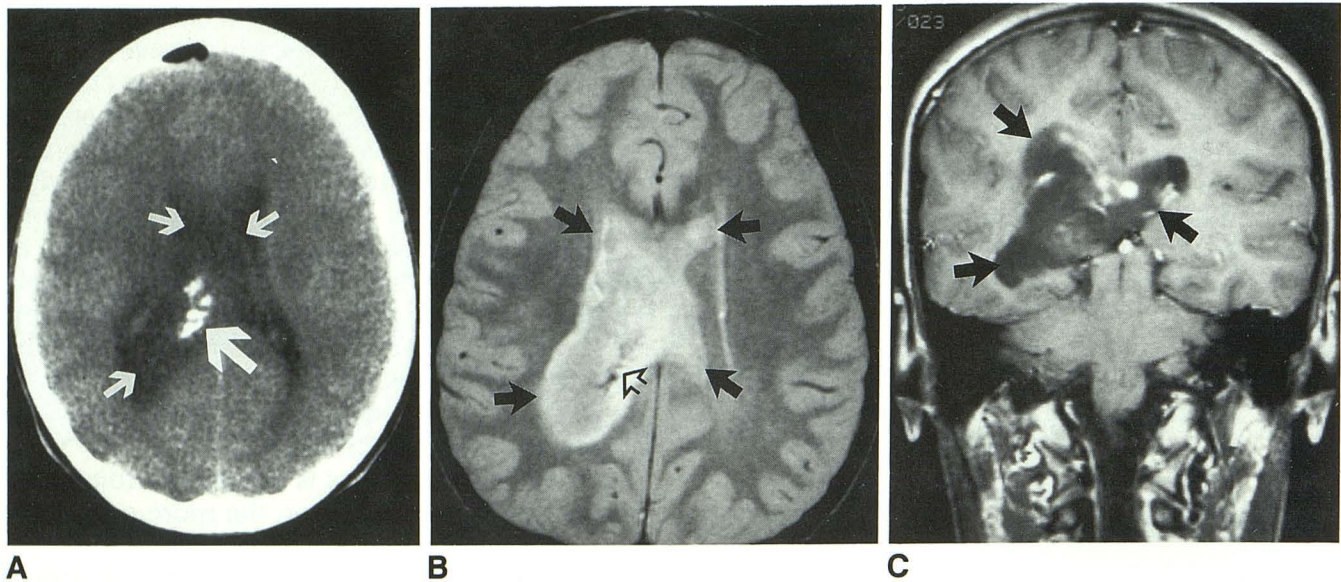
Thirteen-year-old girl with right-sided headaches. Axial, nonenhanced CT (A) shows the poorly defined isodense intraventricular mass (*small white arrows*) and calcifications (*large white arrow*). A small amount of subdural air is present frontally after a biopsy. Axial proton density MR (B) demonstrated a right lateral intraventricular hyperintense mass (*black arrows*) expanding the ventricle and extending across the midline into the left lateral ventricle. Calcifications are also demonstrated (*open arrow*). Coronal enhanced T1-weighted MR (C) demonstrates the bilateral hypointense intraventricular tumor (*black arrows*) and mild to moderate nodular enhancement.
